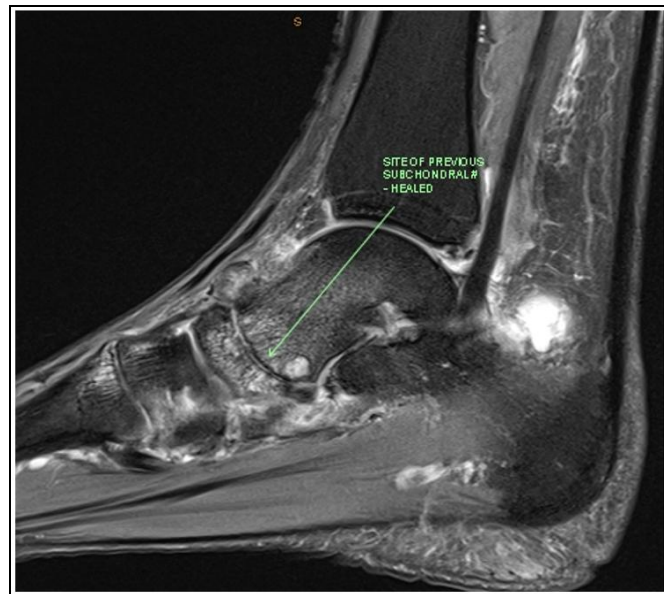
Sagittal FS T2 MRI post stem cell therapy showing remodeling and complete healing of the subchondral fracture.
